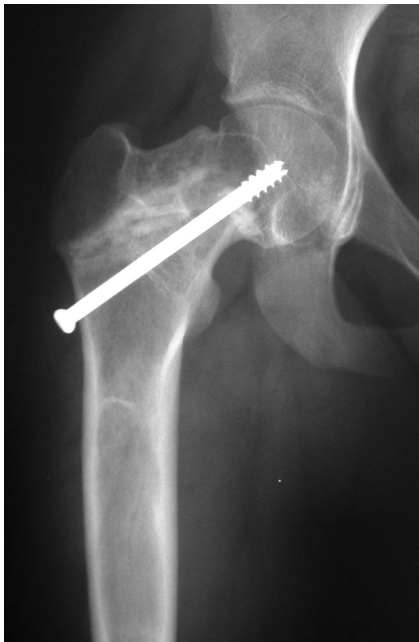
Anteroposterior radiograph of a pathologic fracture of the proximal femur treated with bone grafting and internal fixation. Only part of the graft seems to remain. (Copyright © Rakesh Donthineni-Rao, MD.)
